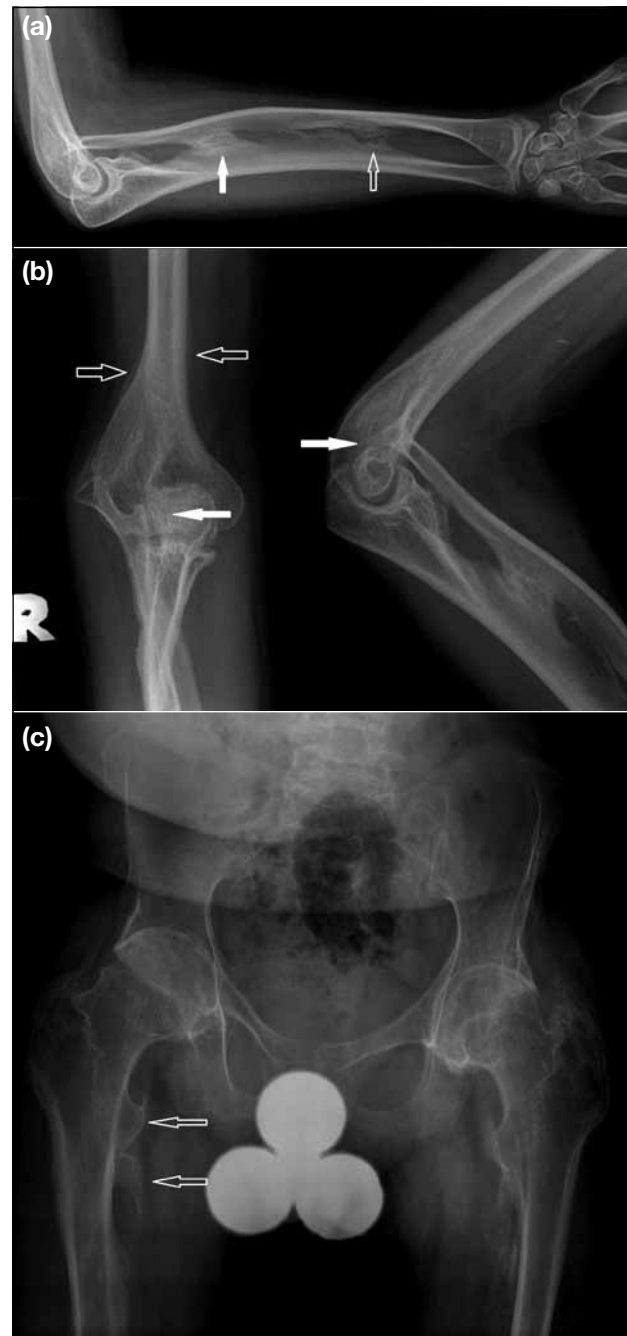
Patient 2: (a) A radiograph of the right forearm shows grade II (open arrow) and grade III (solid arrow) interosseous membrane ossifications. (b) (left) Frontal and (right) lateral radiographs of the right elbow: secondary dislocation of the radial head was seen due to interosseous membrane ossification (solid arrows). Smooth, undulating periosteal reactions were also noted along the medial and lateral aspects of right distal humerus (open arrows). This was a generalised feature seen along various long bones in both patients. (c) A radiograph of the pelvis shows multiple heterotopic ossifications around the pelvic bones, bilateral hip joints, and bilateral proximal femur. Some of them had a spur-like appearance (open arrows).
